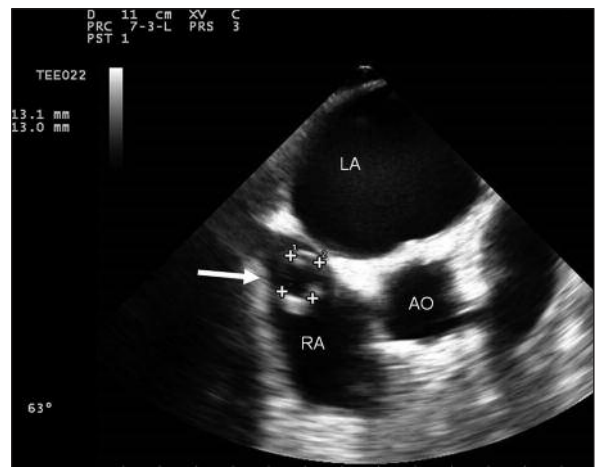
Transesophageal echocardiography in modified short-axis projection showing 13x13 mm cystic mass (arrow) attached to interatrial septum. AO, aorta; LA, left atrium; RA, right atrium.
